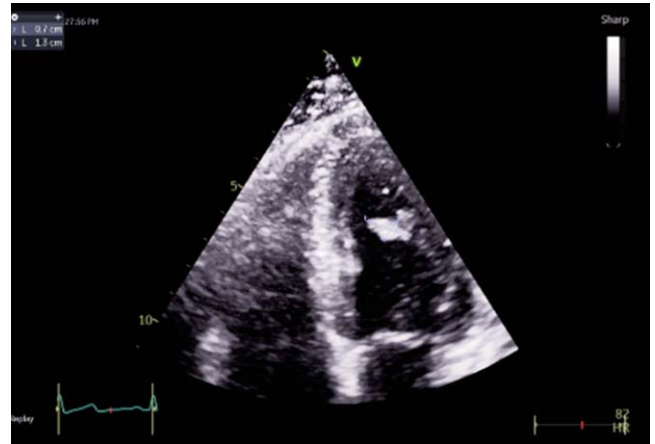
Transthoracic Echocardiography on admission showing 13x7mm vegetation at chordae.
